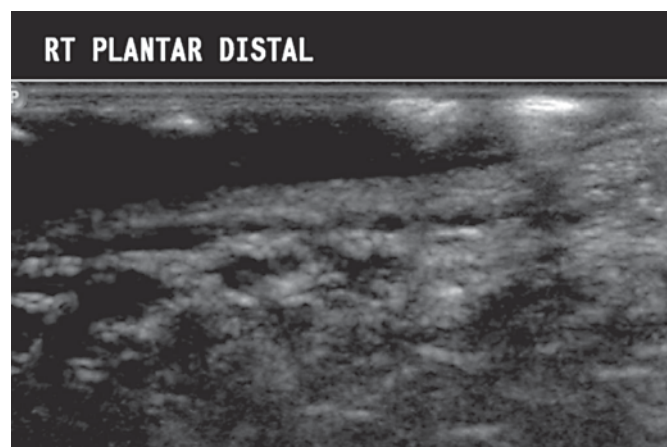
Ultrasound scan performed over the calluses at the distal plantar foot in a PC patient. Hyperechoic dots and lines at the epidermis, above the blister fluid layer, are seen, reflecting hyperkeratosis.
